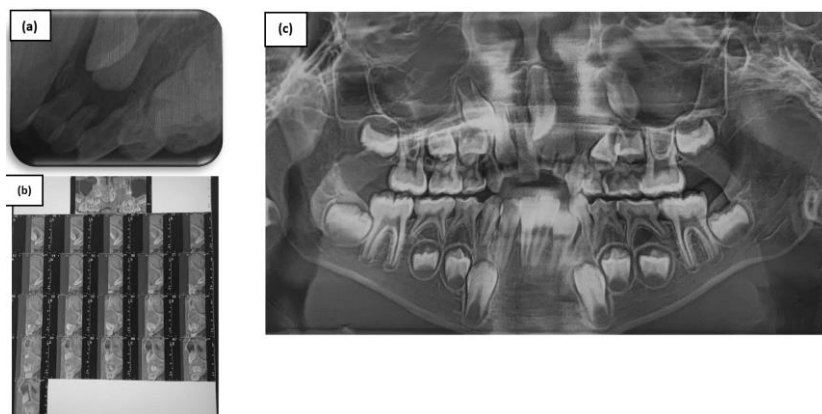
Radiological examination, (a) retroalveolar showing a well-limited radiolucent image, (b) cone beam exposing the limits of the lesion and the rapport with adjacent structures, (c) panoramic radiography showing the germ replacement of the 21 et 23.
